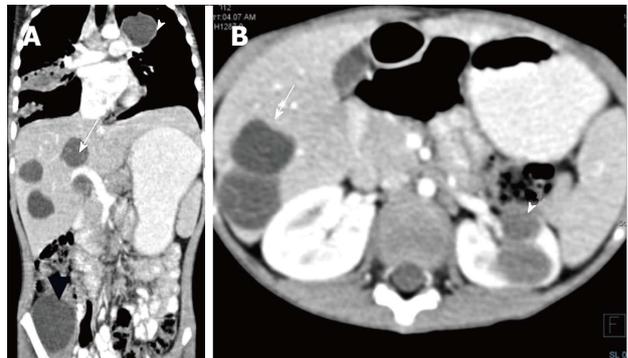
Disseminated hydatidosis. A: Coronal reformed CECT of a 7 years old boy shows multiple hydatid cysts in lung (white arrowhead), liver (arrow) and right iliacus (black arrowhead); B: Axial CECT shows multiple liver (arrow) and renal hydatid cysts (arrowhead). CECT: Contrast-enhanced computed tomography.
